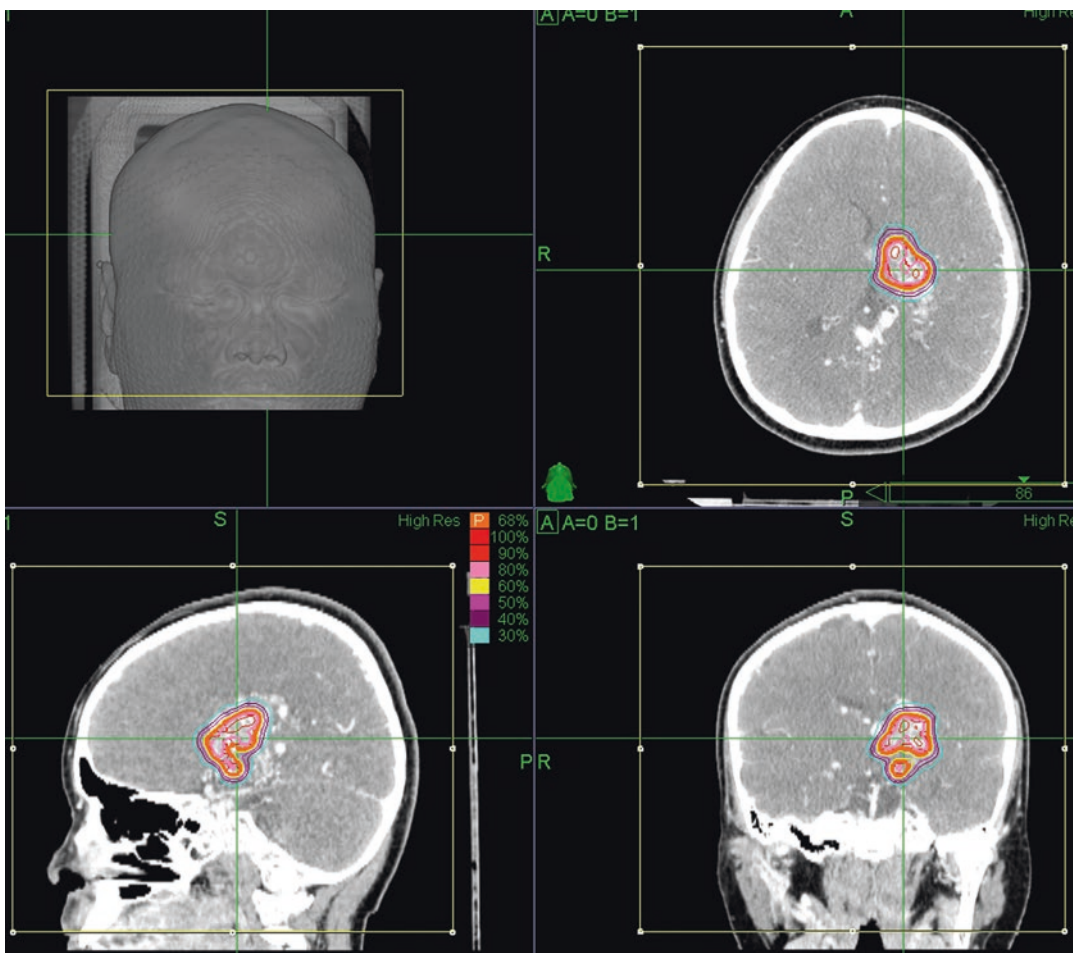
The treatment planning of the AVM in the axial, sagittal, and coronal CT planes
